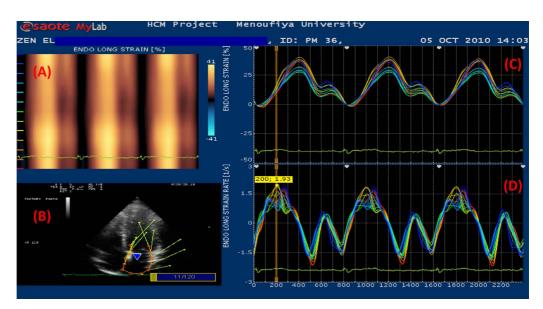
LA strain and strain rate using VVI. A: Curved M-mode of LA longitudinal strain. B: Tracing of the LA endocardial border in apical 4-ch view showing velocity vectors. C: Strain and D: strain rate versus time curves in septal, lateral and LA roof segments. The averaged LA  $SR_{svs}$  is 1.9  $s^{-1}$ .
